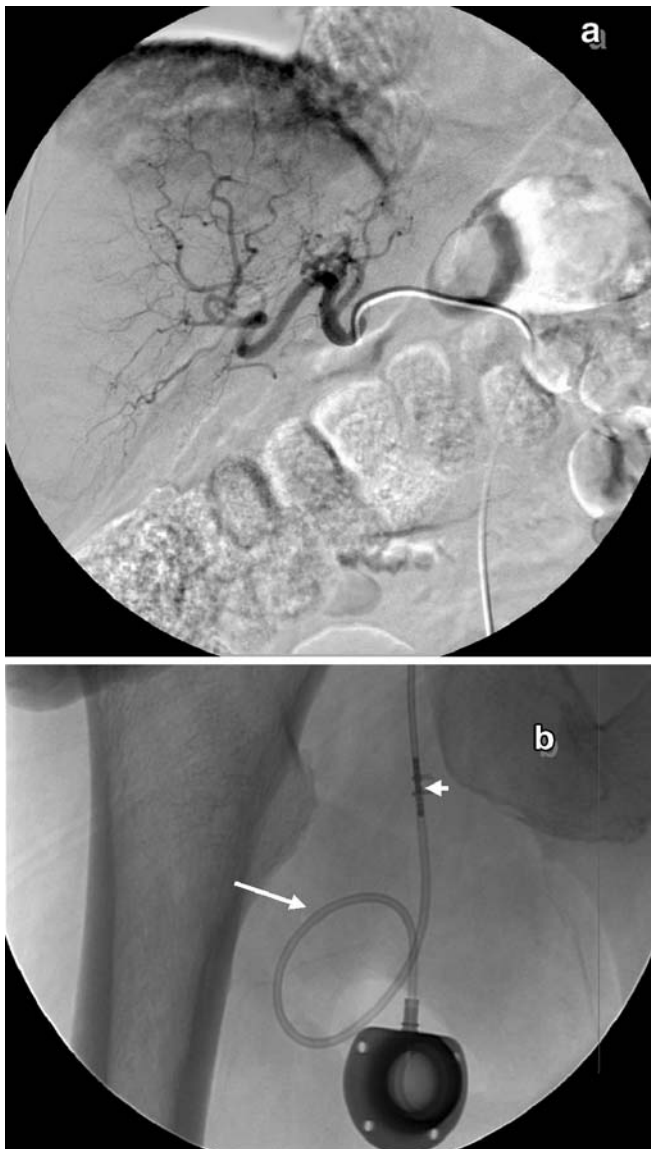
a Control arteriogram after placing a Cobra catheter in the hepatic artery proper distal to the gastroduodenal artery yet allowing perfusion of both hepatic lobes. b Plain radiograph of the port placed in the upper thigh. The connecting catheter (*long arrow*) links the port to the Cobra catheter. The point of connection is secured by metal clips (*short arrow*)
